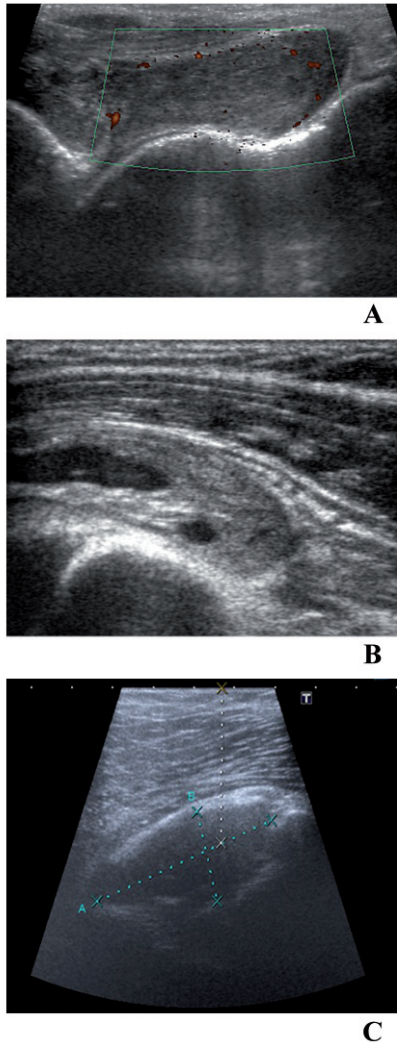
Pigmented villonodular synovitis, localized type in the tendon sheath of the index. Lineal (A, B) and ultrasound convex transducer, with (A) and without Doppler (B, C).
